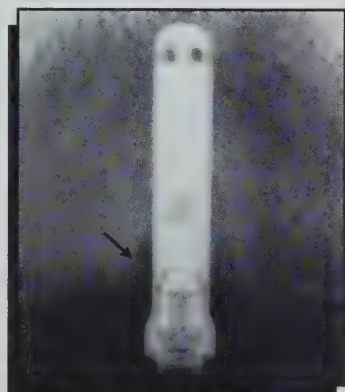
Radiographic example of Stage IV diagnosis and bony defect.
